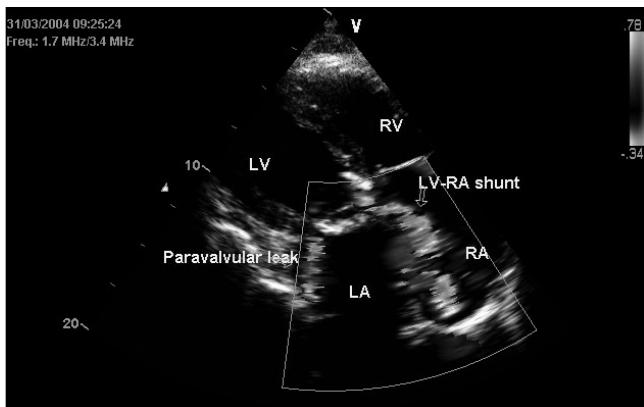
Transthoracic echocardiographic examination at apical four-chamber view that shows paravalvular leak to the left atrium (LA) and left ventricular (LV) to right atrial (RA) shunt. RV Right ventricle
